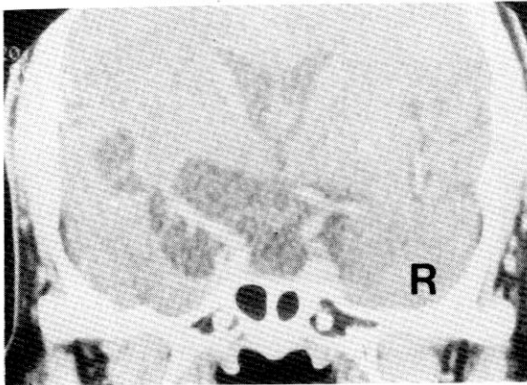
Coronal CT scan of the sella with IV contrast infusion: multilobulated cystic lesion in the suprasellar cistern and the left sylvian cistern with extension into the pituitary fossa. A thin rim of the compressed pituitary gland is noted.
